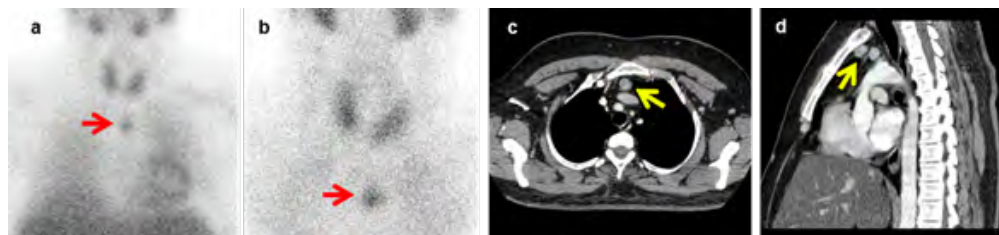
Dmonstrates the scintigraphic MIBI and the enhanced CT images of an ectopic parathyroid adenoma revealed in the upper anterior mediastinum in a pHPT patient. The MIBI image (a) of a large field anterior view of the neck/mediastinum, acquired with a parallel holes collimator, reveals a single abnormal focal activity projected in the upper anterior mediastinum (red arrow); the magnified MIBI pinhole image (b) shows no abnormal focus of tracer uptake along the thyroid region, and the single abnormal ectopic focus in the upper mediastinum (red arrow) is better identified as compared to the parallel holes collimator image. The confirmative transversal (c) and sagittal (d) cross-sectional images of the enhanced chest CT reveal a rounded tissue nodule in a retrosternal location (yellow arrows).
